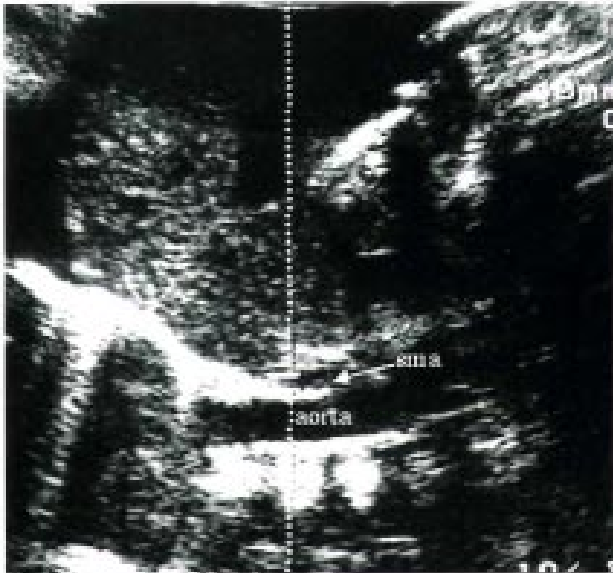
Ultrasound study of upper gastrointestinal system revealed the narrowing of aortomesenteric angle. It was found approximately about 15 degrees.
